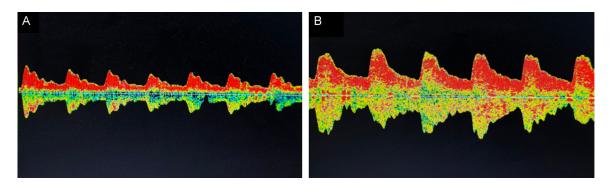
Representative TCD waveforms 14 days after treatment. A. A 56-year-old male patient from the Atorvastatin group showing Vs of 56.5 cm/s, Vm of 33.6 cm/s, and Pl of 1.25. B. A 60-year-old male patient from the Combination group showing Vs of 76.6 cm/s, Vm of 43.8 cm/s, and Pl of 1.13. TCD: transcranial Doppler, Vm: mean flow velocity, Vs: peak systolic velocity, Pl: pulsatility index.
